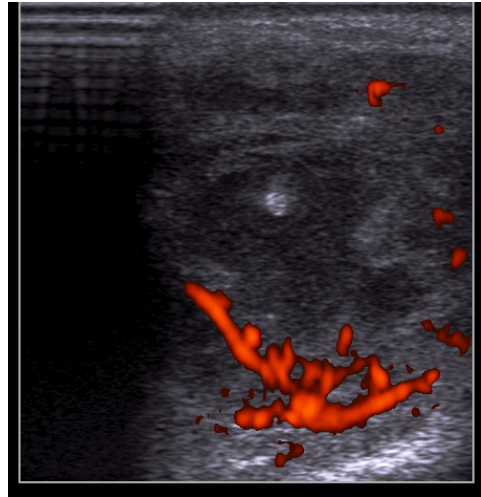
Power doppler sonogram of malignant lymph node on the neck with necrotic focus in tongue carcinoma (findings confirmed by PH analysis)
